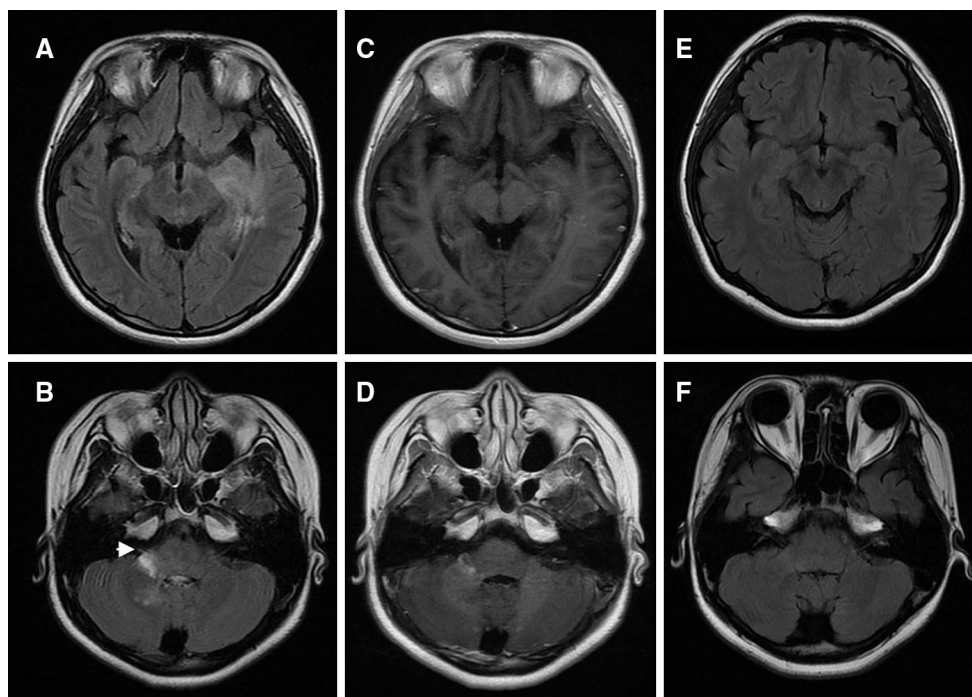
Magnetic resonance images of the patient in relapse before and after immunotherapy. a, b Before immunotherapy, hyperintensified lesions were observed in the left temporal lobe, left hippocampus and parahippocampal gyrus, and the right cerebellum and right
